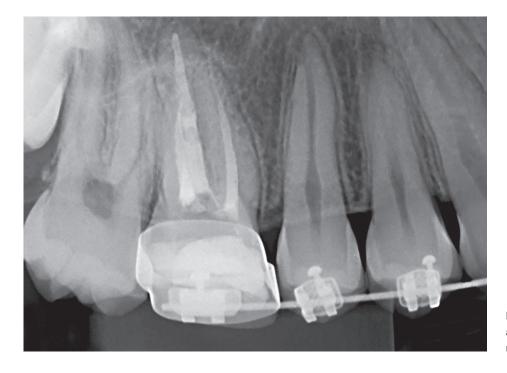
Radiographic image of tooth 16 after 2 years of surgery revealing complete regression of cystic lesion.
